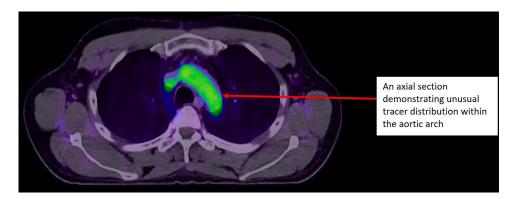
An axial section of AM's PSMA PET scan demonstrating radionuclide within the aortic arch.
